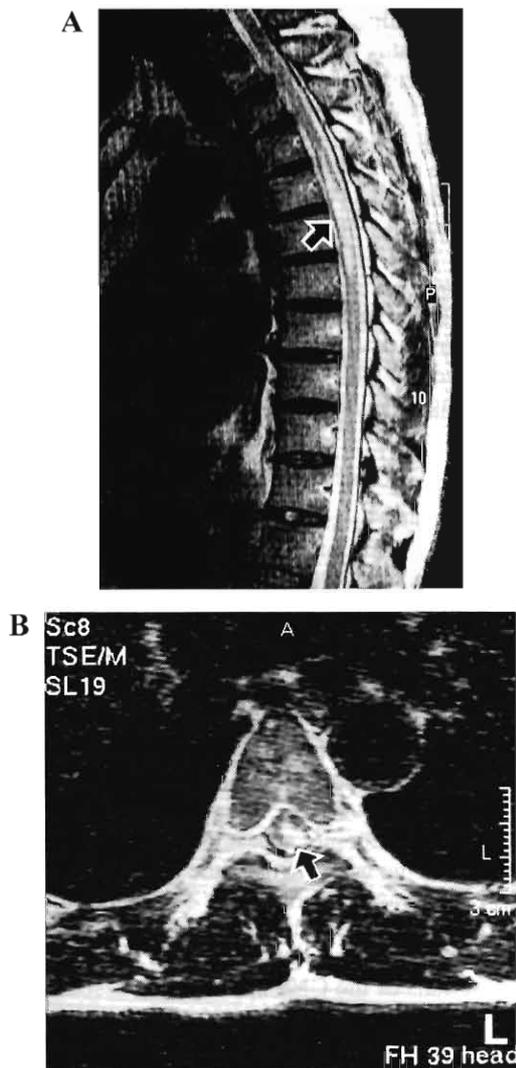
MRI of HSV-1 myelitis
